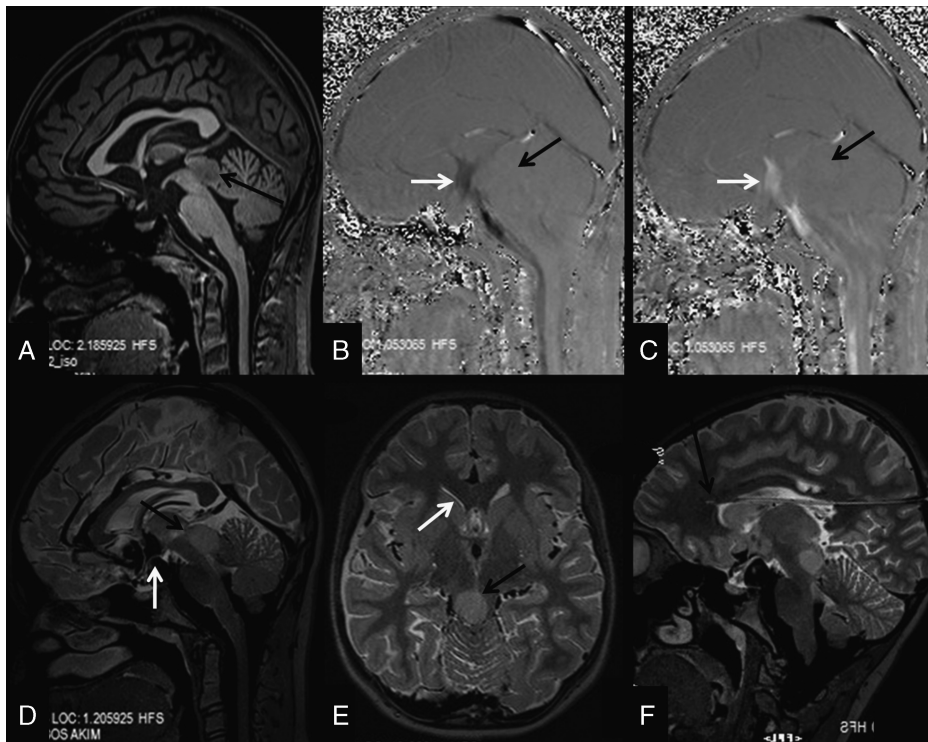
3D-MPRAGE (A), PC-MRI (B, C), and 3D-SPACE with variant FA mode (D–F) images of an 11-year-old girl with aqueduct stenosis. In sagittal MPRAGE image (A), tectal glioma (arrow) is shown causing the aqueduct stenosis. In sagittal PC-MRI images (B, C), no flow is detected at the level of aqueduct (black arrows). Flow is present in systolic and diastolic phases at the level of inferior wall of the third ventricle (white arrows in B, C). In the sagittal 3D-MPRAGE image, inferior wall of the third ventricle is not clearly visualized (A). The sagittal 3D-SPACE image (D) clearly shows tectal glioma (black arrow), aqueductal stenosis, and intact inferior wall of the third ventricle (white arrow). Also, morphology of tectal glioma is well demarcated on axial reformatted 3D-SPACE image (black arrow, E). Also in this image, ventriculomegaly, known to be present previously, is shown to regress after placement of shunt catheter (white arrow, E). On the other hand, in the sagittal oblique reformatted image, distal end of the shunt catheter is shown to pass through corpus callosum (black arrow, F).
